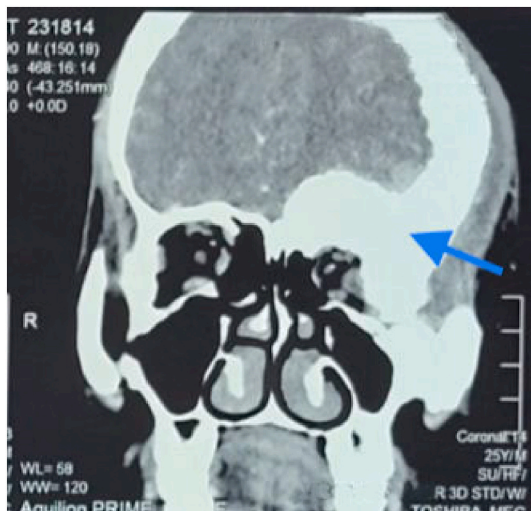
CT brain shows supraorbital bony thickness.
